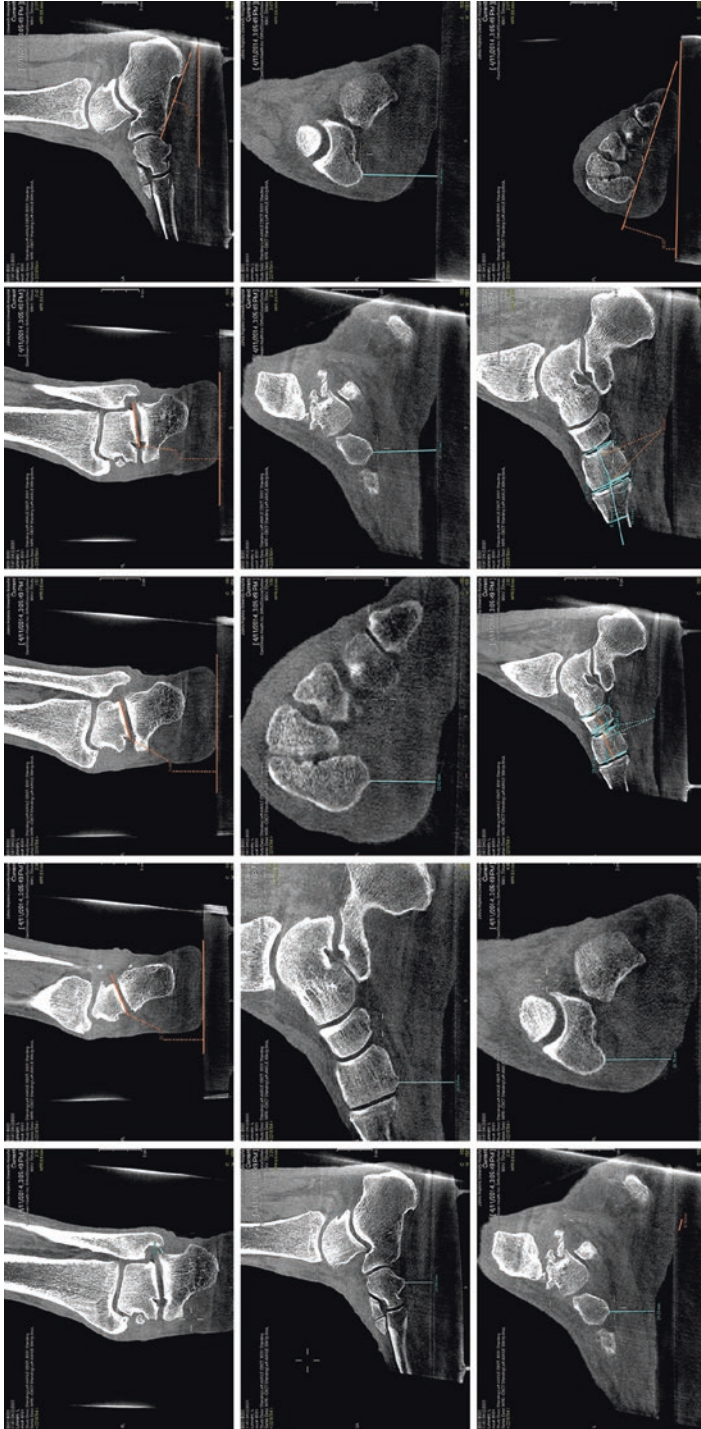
Hindfoot, midfoot, and forefoot alignment measurements using weight-bearing computed tomography. (a) Calcaneofibular distance in coronal plane. (b) Subtalar horizontal angle in coronal plane. (c) Calcaneal inclination angle in sagittal plane. (d) Cuboid-floor distance in sagittal plane. (e) Cuneiform-floor distance in sagittal and coronal planes. (f) Navicular-skin distance in sagittal and coronal planes. (g) Navicular-1st metatarsal angle in sagittal plane. (h) Cuneiform-1st metatarsal angle in sagittal plane. (i) Navicular-cuneiform angle in sagittal plane. (j) Cuneiform-cuneiform angle in coronal plane. (k) Forefoot arch angle in coronal plane
